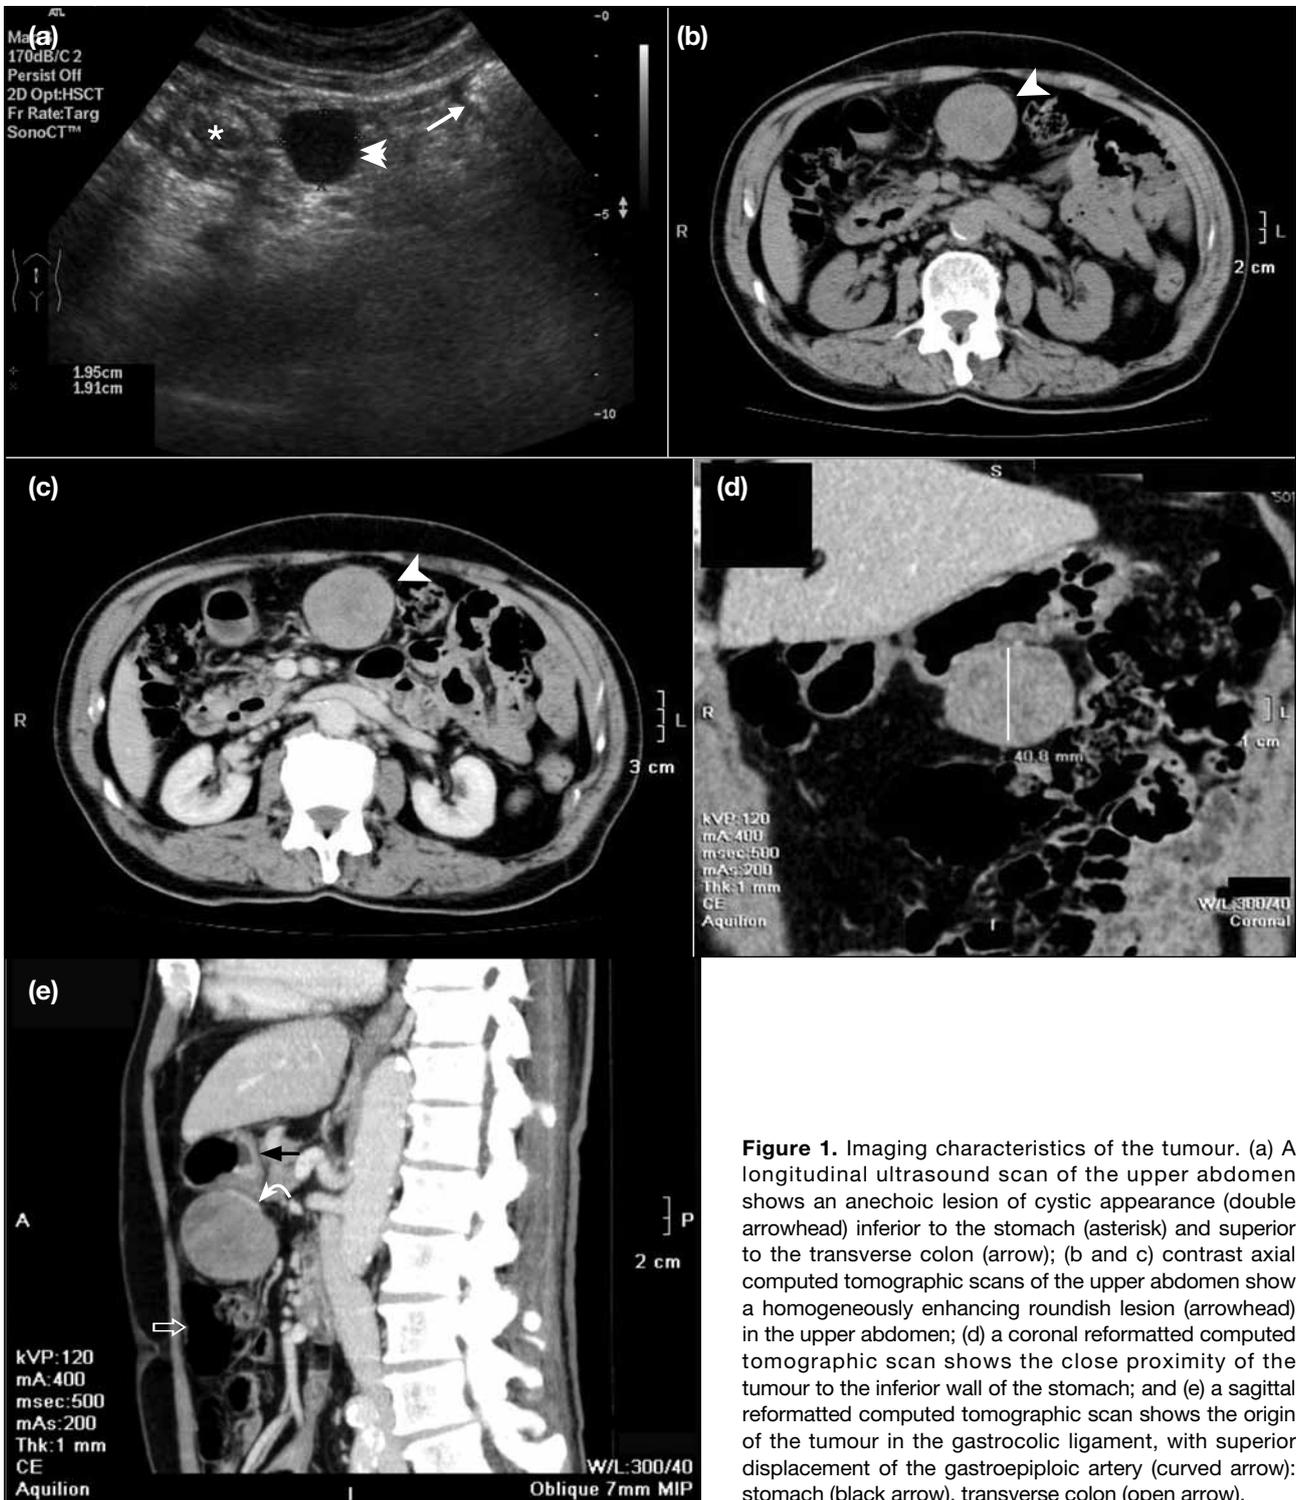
Imaging characteristics of the tumour. (a) A longitudinal ultrasound scan of the upper abdomen shows an anechoic lesion of cystic appearance (double arrowhead) inferior to the stomach (asterisk) and superior to the transverse colon (arrow); (b and c) contrast axial computed tomographic scans of the upper abdomen show a homogeneously enhancing roundish lesion (arrowhead) in the upper abdomen; (d) a coronal reformatted computed tomographic scan shows the close proximity of the tumour to the inferior wall of the stomach; and (e) a sagittal reformatted computed tomographic scan shows the origin of the tumour in the gastrocolic ligament, with superior displacement of the gastroepiploic artery (curved arrow): stomach (black arrow), transverse colon (open arrow).
